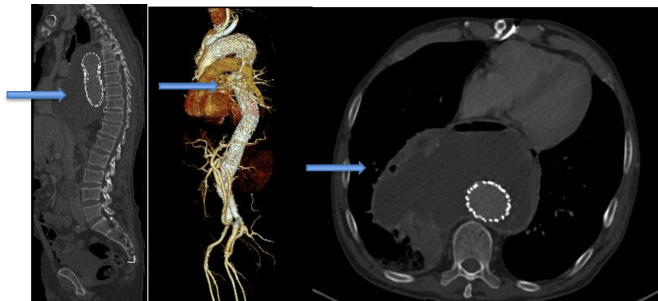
Initial computed tomography (CT) scan in 2015 with infected aneurysm bag (blue arrow).
